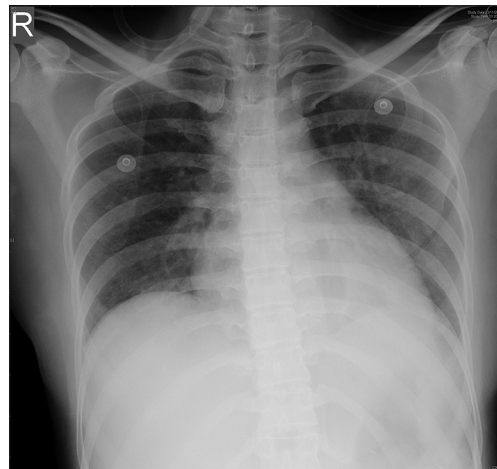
Chest radiograph of patient one at discharge
